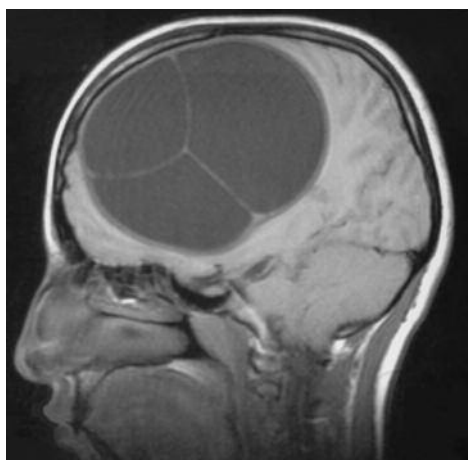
MRI scan of head shows multiple cerebral cysts on sagittal plan. Note a huge mass occupying multiple lobes.
